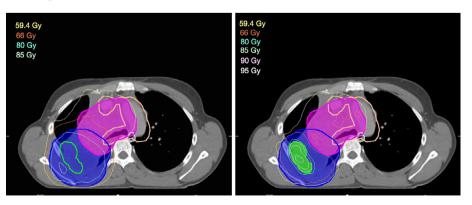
Panel A shows a dose distribution for escalation to the primary tumour as a whole (PTV<sub>prim</sub> in blue). Panel B shows a dose distribution escalation to the PET-subvolume (PTV<sub>PET</sub> in green,  $\geq$ 50% SUV<sub>max</sub> on patients' pre-treatment <sup>18</sup>F-FDG-PET/CT) within the primary tumour for the same patient. The two plans were required to have an equal mean lung dose, delivering 24 fractions in the range of 3.0-5.4 Gy, determined by predefined organ at risk constraints. As the PET-subvolume is generally smaller than the whole tumour, the fraction dose in this plan could generally be escalated higher before reaching the same mean lung dose. Lymph nodes (PTV<sub>In</sub> in pink) did not receive a dose escalation, but were planned to receive 66 Gy in the same 24 fractions. Organ at risk constraints were prioritised over fraction dose escalation. The mediastinal envelope plus a 5 mm margin, used as planning risk volume, is represented by the salmon line. PTV=planning target volume.
